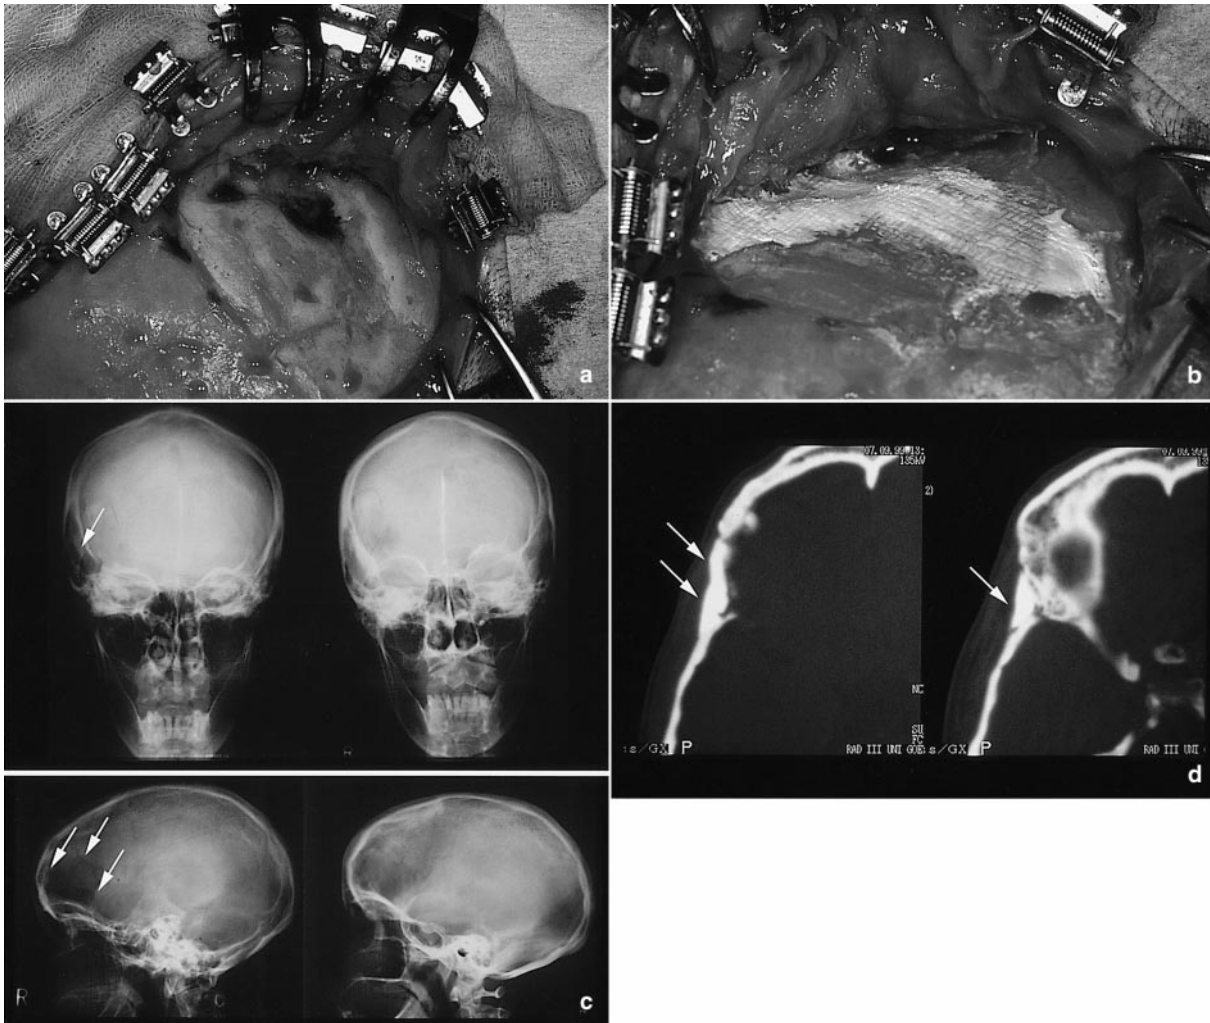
(a, b) Intra-operative site of the 38-year-old woman with a cosmetically disfiguring defect after pterional craniotomy. Placement of HAC and complete correction of the defect. (c) Pre- and postoperative frontal and lateral plain roentgenographs demonstrate the defect before and after application of HAC (white arrows). (d) Postoperative CT scans show the corresponding radio-opaque HAC filling the defect homogeneously
